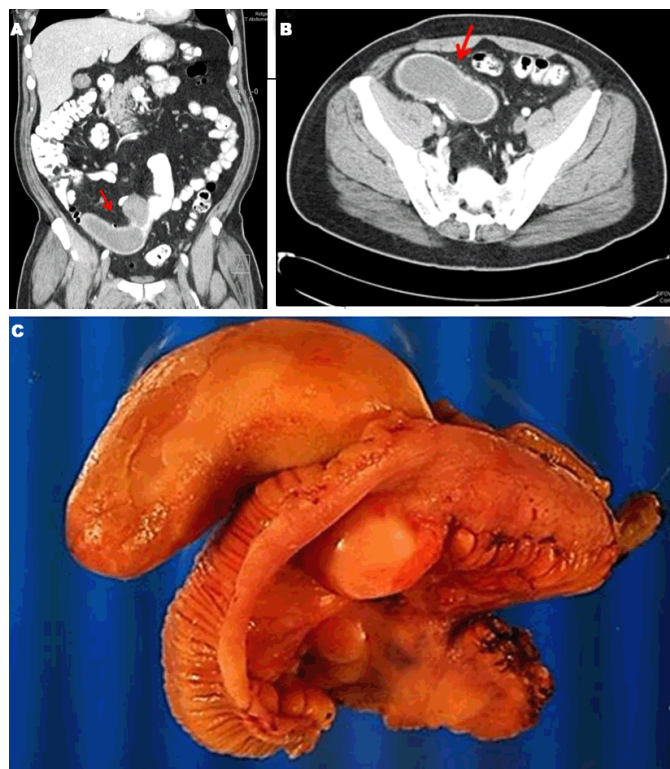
(A–C): Coronal and axial CT scan of abdomen and pelvis revealing a tubular, elongated ileal mass (red arrows) causing partial obstruction and intussusception (A, B). Gross image with a large solid tan-pink elongated luminal and extraluminal tumor mass protruding into the small bowel lumen on one side and pushing the serosal surface on the other side (C).
